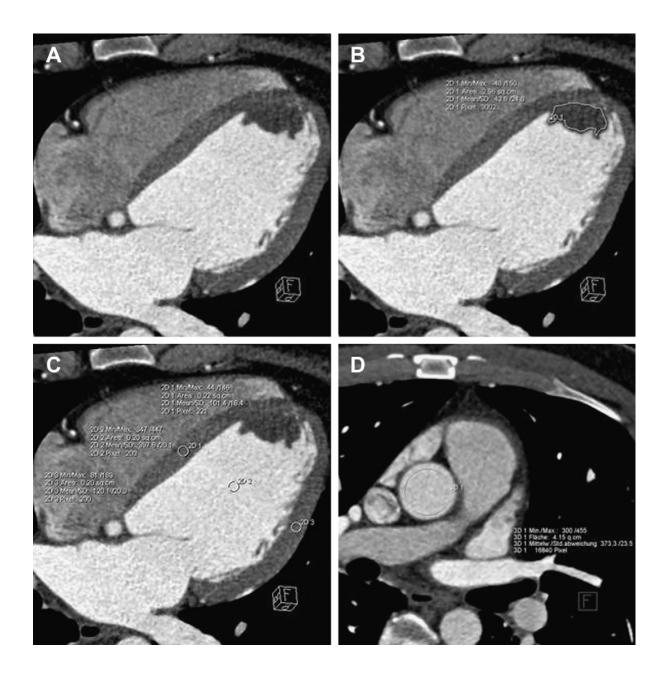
Attenuation measures of left ventricular thrombus seen by Computed Tomography *imaging.* Extracted from (34).
